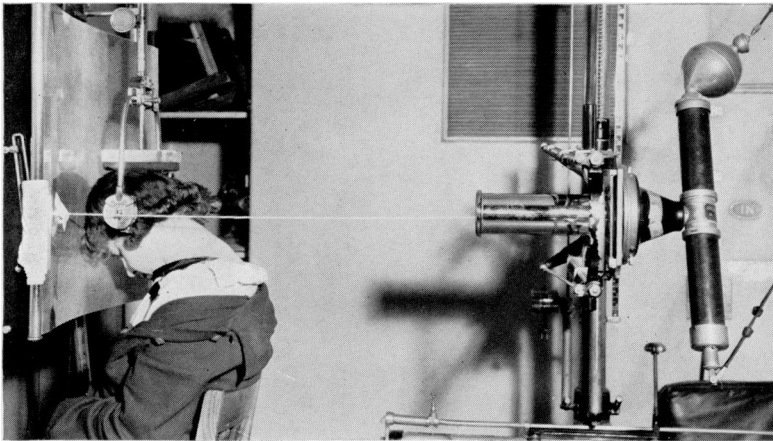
Photograph to show the arrangement of patient, x-ray tube, and Potter-Bucky diaphragm for the "fronto-vertex projection" (compare Fig. 2). The arrangement of the apparatus and the positioning of the patient are far easier than in the case of the opposite direction of projection, the so-called "occipital projection." Since this technic is designed with particular reference to delineation of the occipital bone and since this part is at a distance from the film, the x-ray tube focal spot must be of the smallest and the target-film distance must be ample. We have found this type of roentgen examination very informative.
